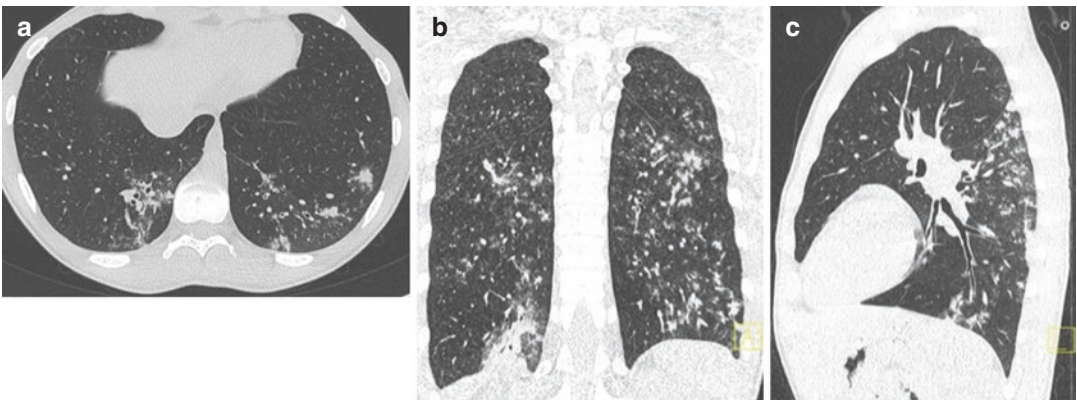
Atypical contusion areas in the posterior segments of the inferior lobes. Post-traumatic CT-scan in axial (a), coronal (b), and sagittal (c) reconstructions.
